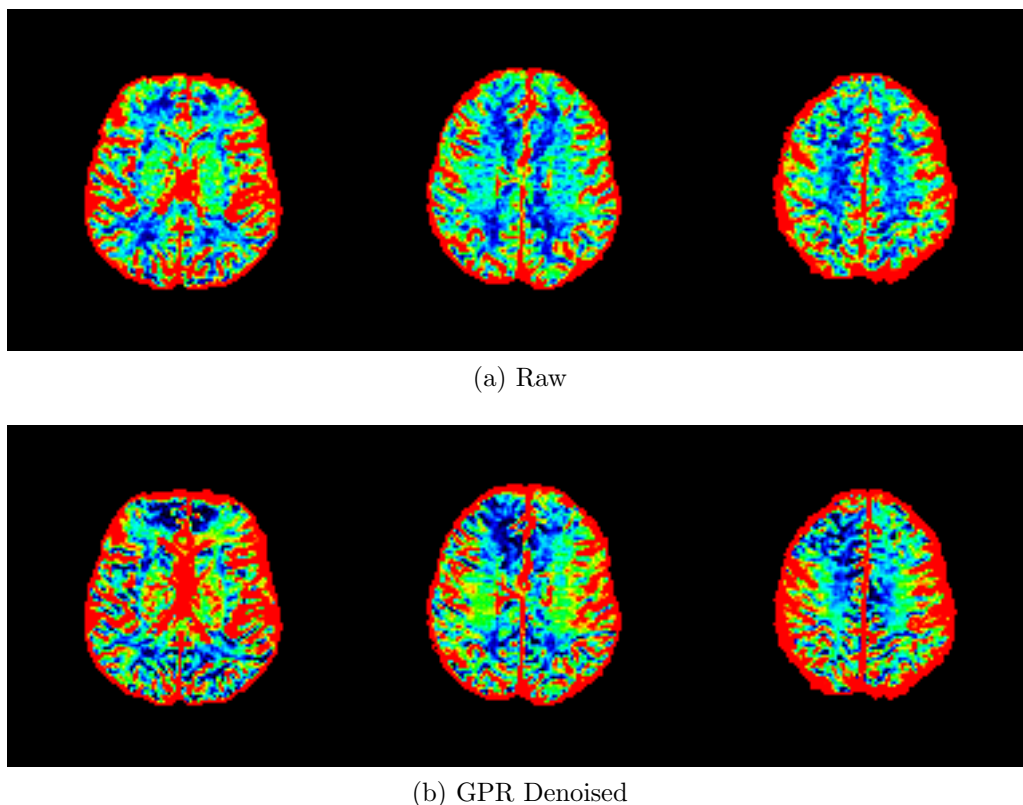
Comparison of Raw and GPR denoised CBF for MRI
